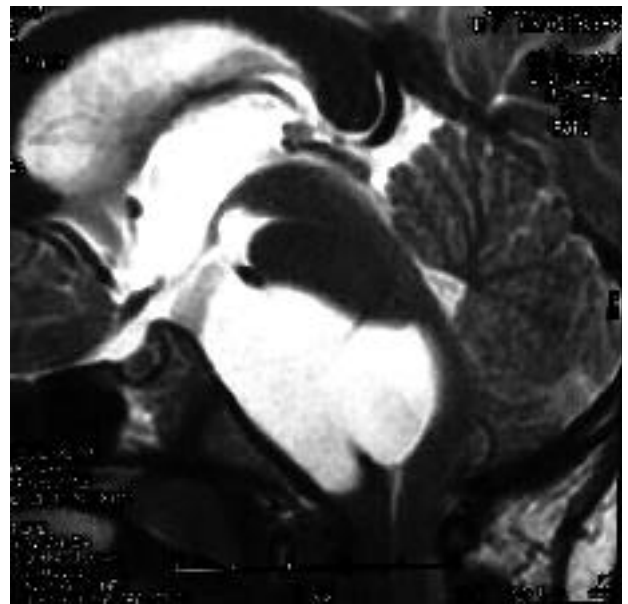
T2-weighted MR sagittal image shows a fluid intensity signal within the mass, suggestive of a cystic lesion. Severe posterior displacement of the brainstem is noted.
